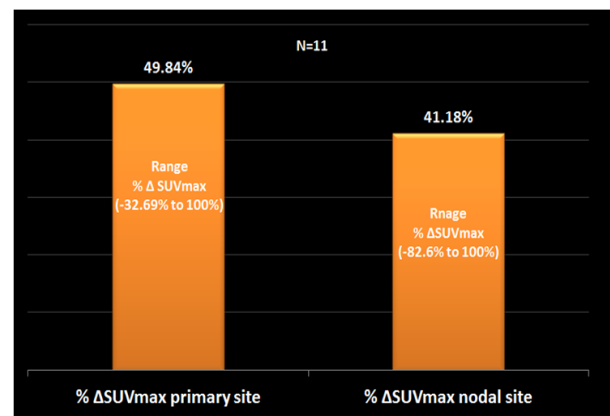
Median % Change in SUV<sub>max</sub> Over Primary and Nodal Sites of Esophageal Cancer Patients between Baseline and Post-nCR <sup>18</sup>F-FDG PET/CT Studies
